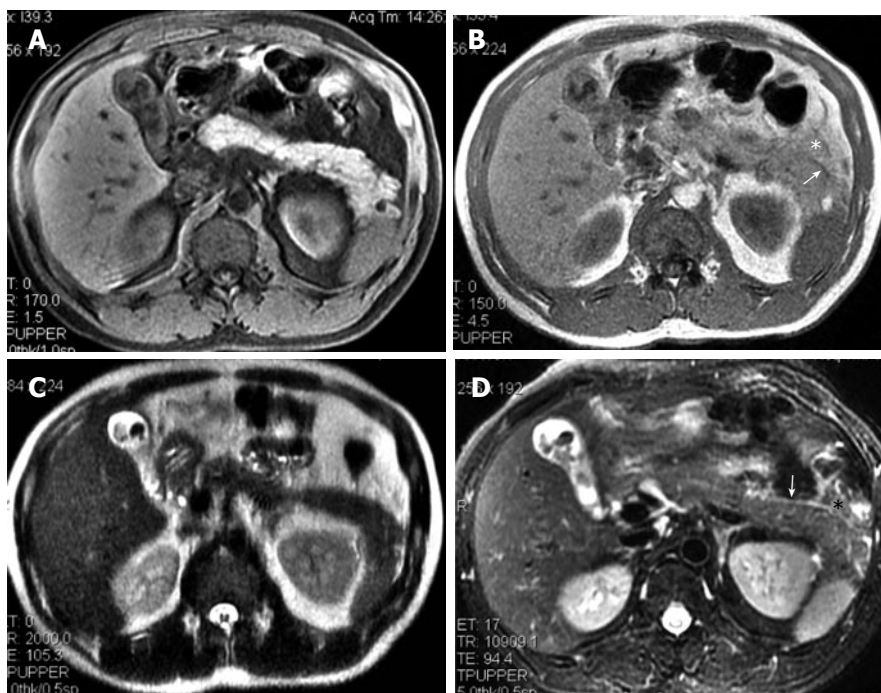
A 45-year-old woman with IEP and cholelithiasis. (A) SPGR fat-suppressed T1-weighted (TR/TE = 170/1.6 ms) image shows normal pancreatic signal intensity. GRE in-phase (TR/TE = 150/4.4 ms) (B) and SSFSE T2 weighted (TE = 90 ms); (C) images show the pancreatic fascia plane (arrows) and the peripancreatic fat stranding (asterisk), which appear more extensive on R-T T2-weighted (TR/TE = 12 300/98 ms) image (D).
